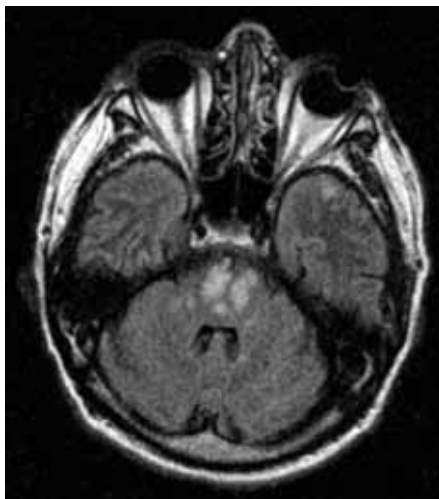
MRI show acute and severe pontine infarction involving more than two thirds of the pons.
